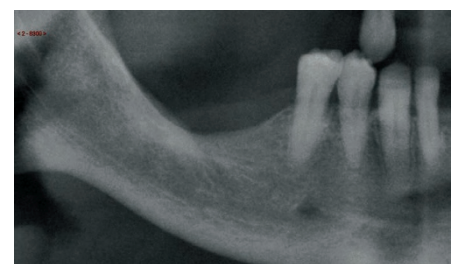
Radiograph taken in December 2011
